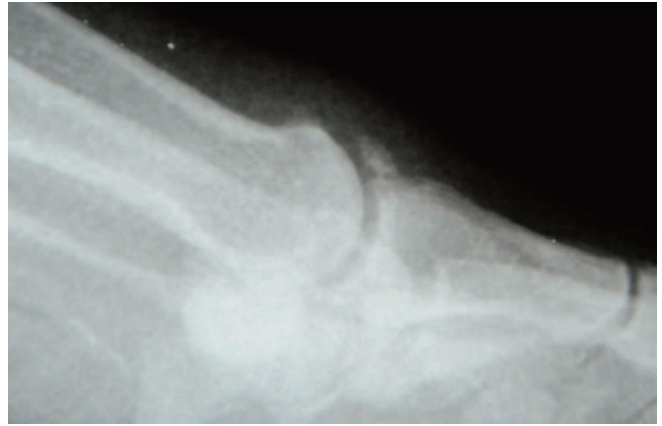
Case Study 2. Preoperative lateral radiograph.
